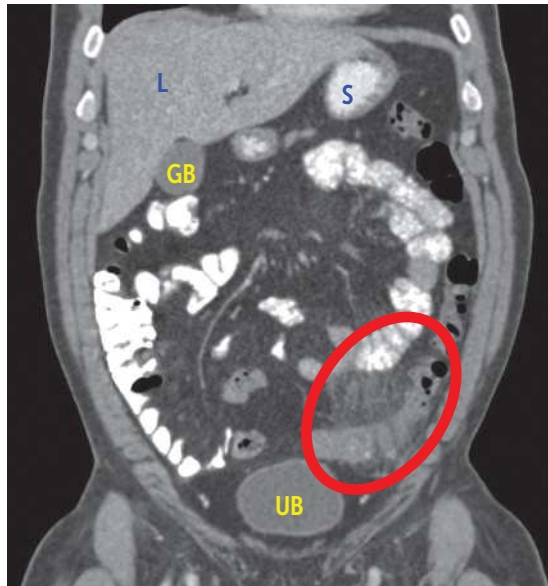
Acute diverticulitis. Coronal reconstruction from a contrast-enhanced CT demonstrates sigmoid diverticula with perisigmoid inflammatory “fat stranding.” The area of abnormality is circled in red. (*L*, liver; *S*, stomach; *GB*, gallbladder; *UB*, urinary bladder.) (Reproduced with permission from USMLE-Rx.com.)
